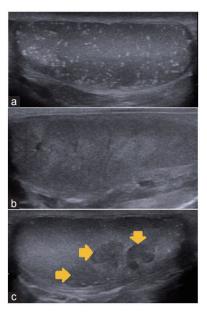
Ultrasonographic abnormalities that may be present in men at risk for testicular germ cell tumors. (a) Testicular microlithiasis in the parenchyma of the testis. (b) Inhomogeneous parenchyma of the testis. (c) Hypo-echoic lesions in the parenchyma of the testis.
